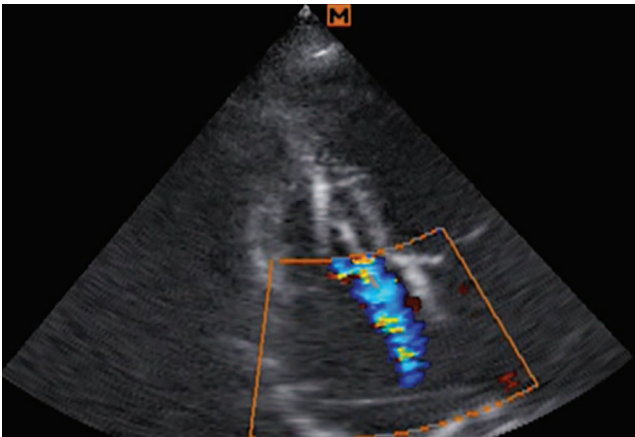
Apical four-chamber view. Color Doppler mapping mode. Tricuspid regurgitation (Blue flow)
